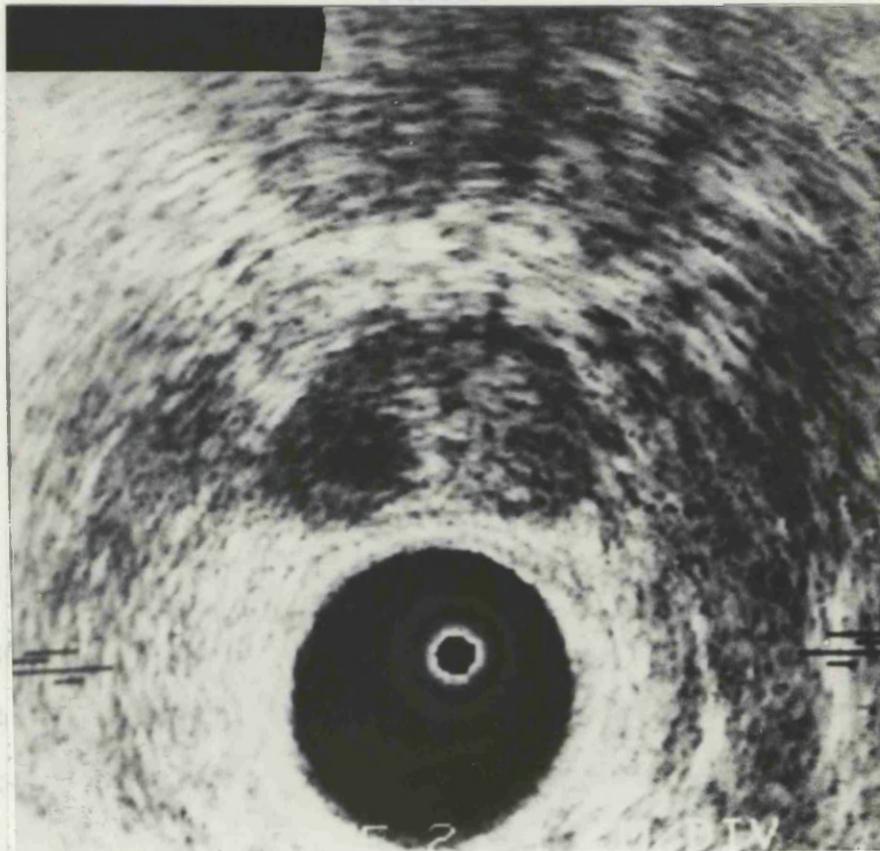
Capsular thickening (CT) in a prostatic ultrasonograph
